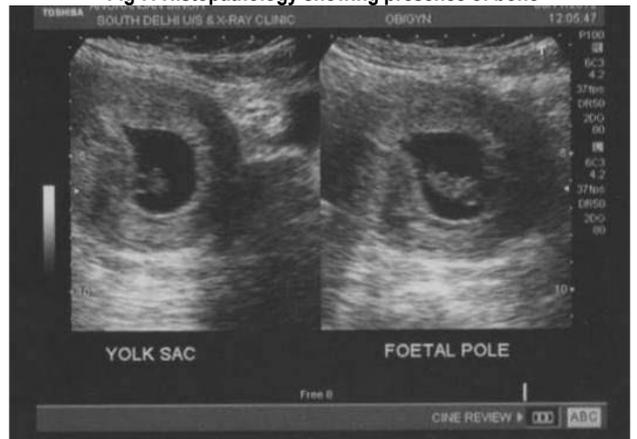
Ultrasound film showing viable pregnancy
